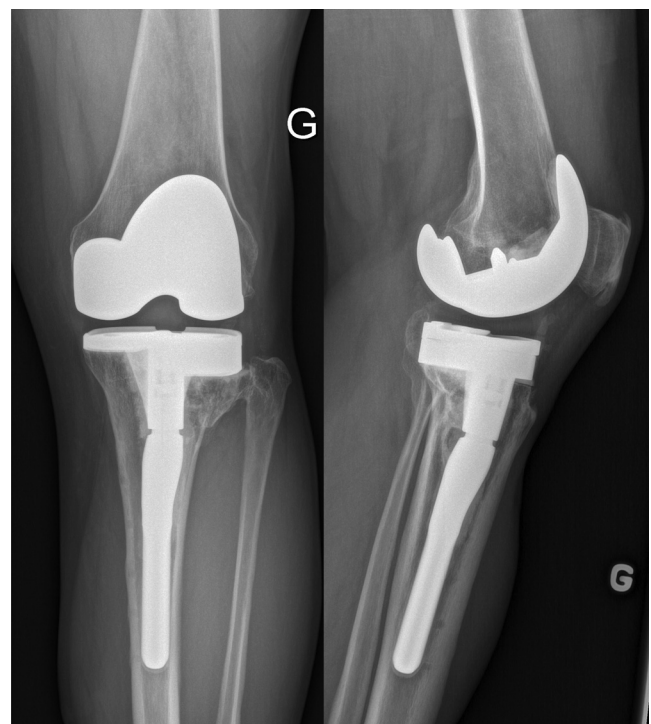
Radiograph of the patient's knee after TKA.
